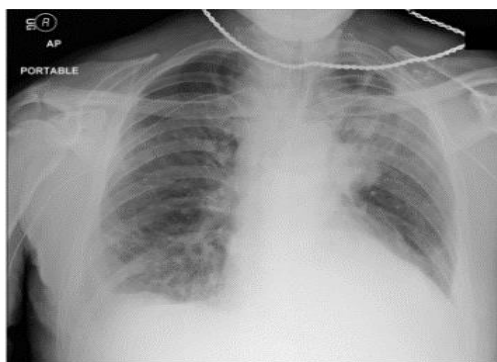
Example of mass in a chest X-ray image (NIH ChestX-ray14 dataset). Dataset.
